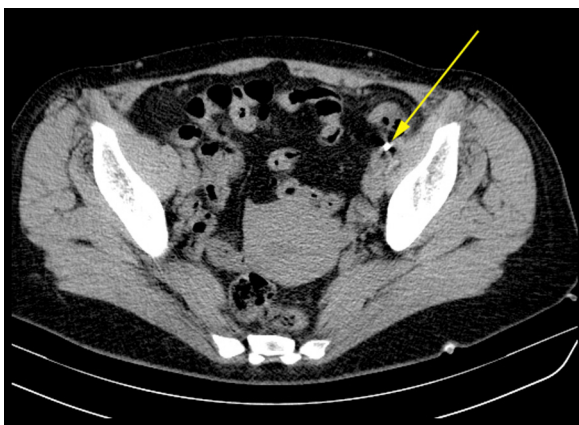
Computed tomography of the lower abdomen showing an air gun pellet in the left iliac region.
